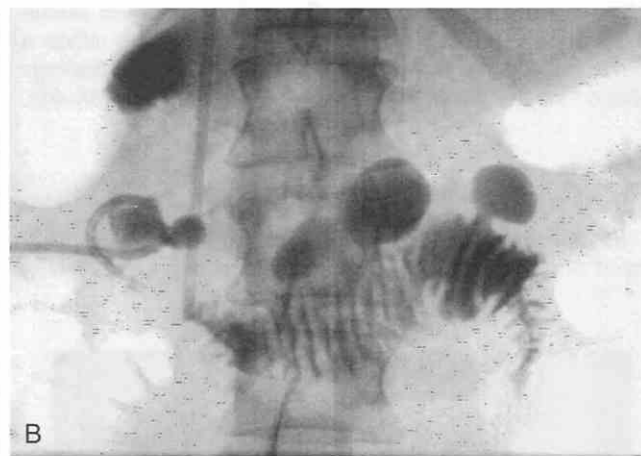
A, CT scan shows a gas collection in the area of the head of the pancreas, which has some ill-defined densities within. Because the patient was febrile, a drainage catheter was inserted (arrow). B, Fluoroscopic study showing contrast material in duodenum and multiple diverticuli; the catheter remains in diverticulum. C, In CT scan obtained after the drainage catheter was removed, the air cavity has reduced in size and has a better-defined margin. This case of duodenal diverticulitis required no further treatment.
